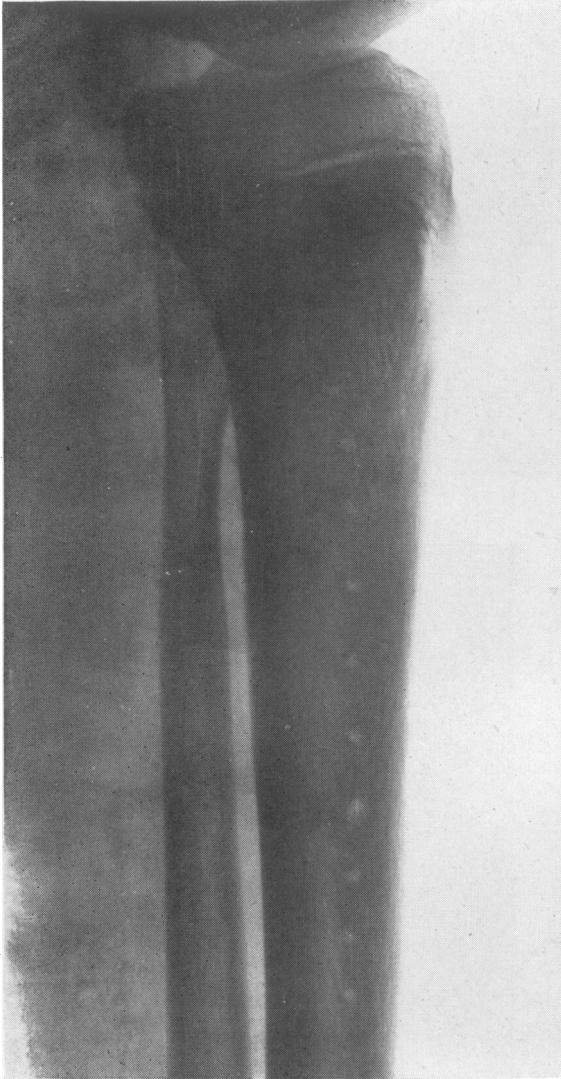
Radiograph of the tibia of a boy aged 12 with acute osteomyelitis of 6 days history. Before operation the bone appeared normal. The drill-holes show the extent of the intra-osseous abscess found at operation the same day. Pus under pressure was found at all but the lowest drill-hole.
